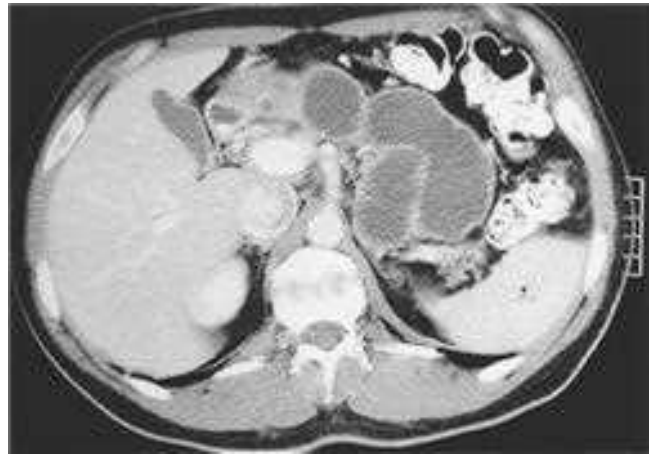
Extensive pseudocyst disease. A computed tomographic scan in a patient with alcoholic chronic pancreatitis demonstrates multiloculated pseudocyst disease.
